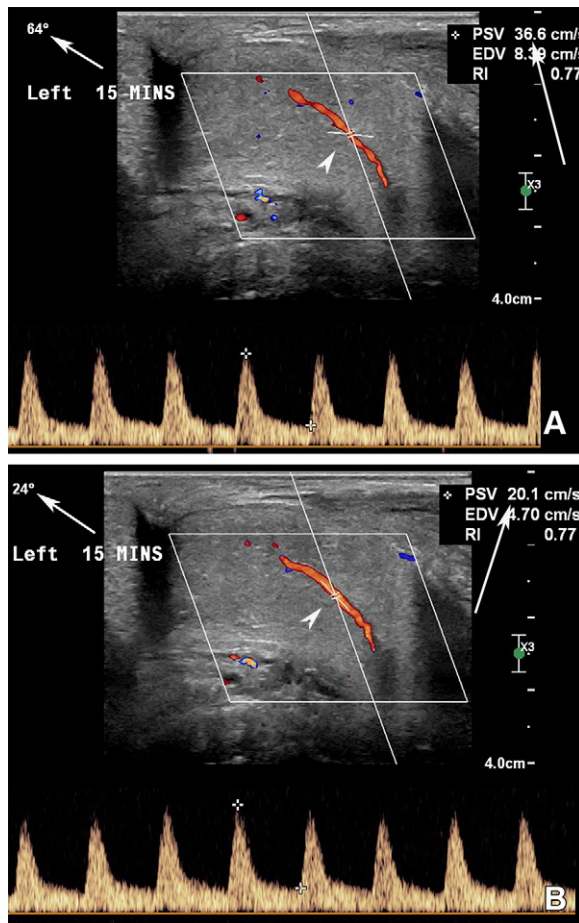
Spectral Doppler US tracing of left cavernosal artery at 15 minutes after intracavernosal injection. (A) Note the uncorrected Doppler US angle (arrowhead) of 64° (short arrow), resulting in an apparent normal peak systolic velocity of more than 35 cm/sec (long arrow). (B) Doppler US image shows the angle corrected (arrowhead) to 24° (short arrow) by using the heel-toe maneuver of the transducer, resulting in a more accurate peak systolic velocity reading of 20 cm/sec (long arrow) indicative of arterial insufficiency in this patient with ED.
